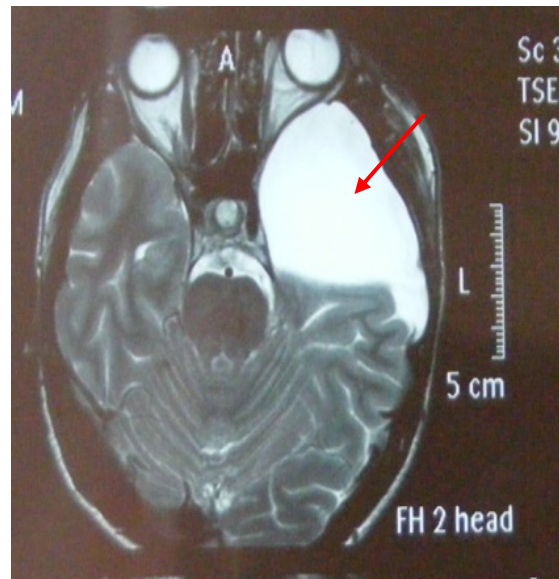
MRI – aspect of Gallasi II left temporo-insular arachnoid cyst
